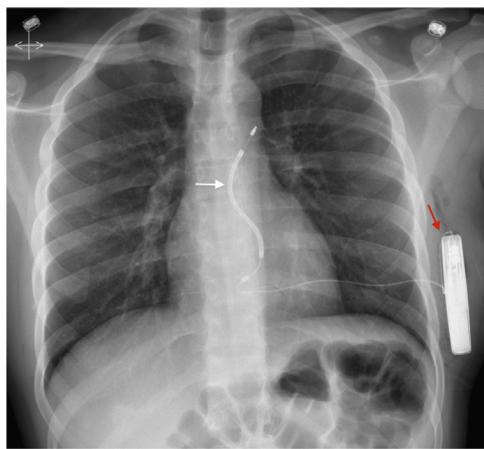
Anteroposterior chest radiograph demonstrating subcutaneous implantable cardiac defibrillator system in situ with the single subcutaneous electrode (white arrow) and pulse generator delineated (red arrow).
